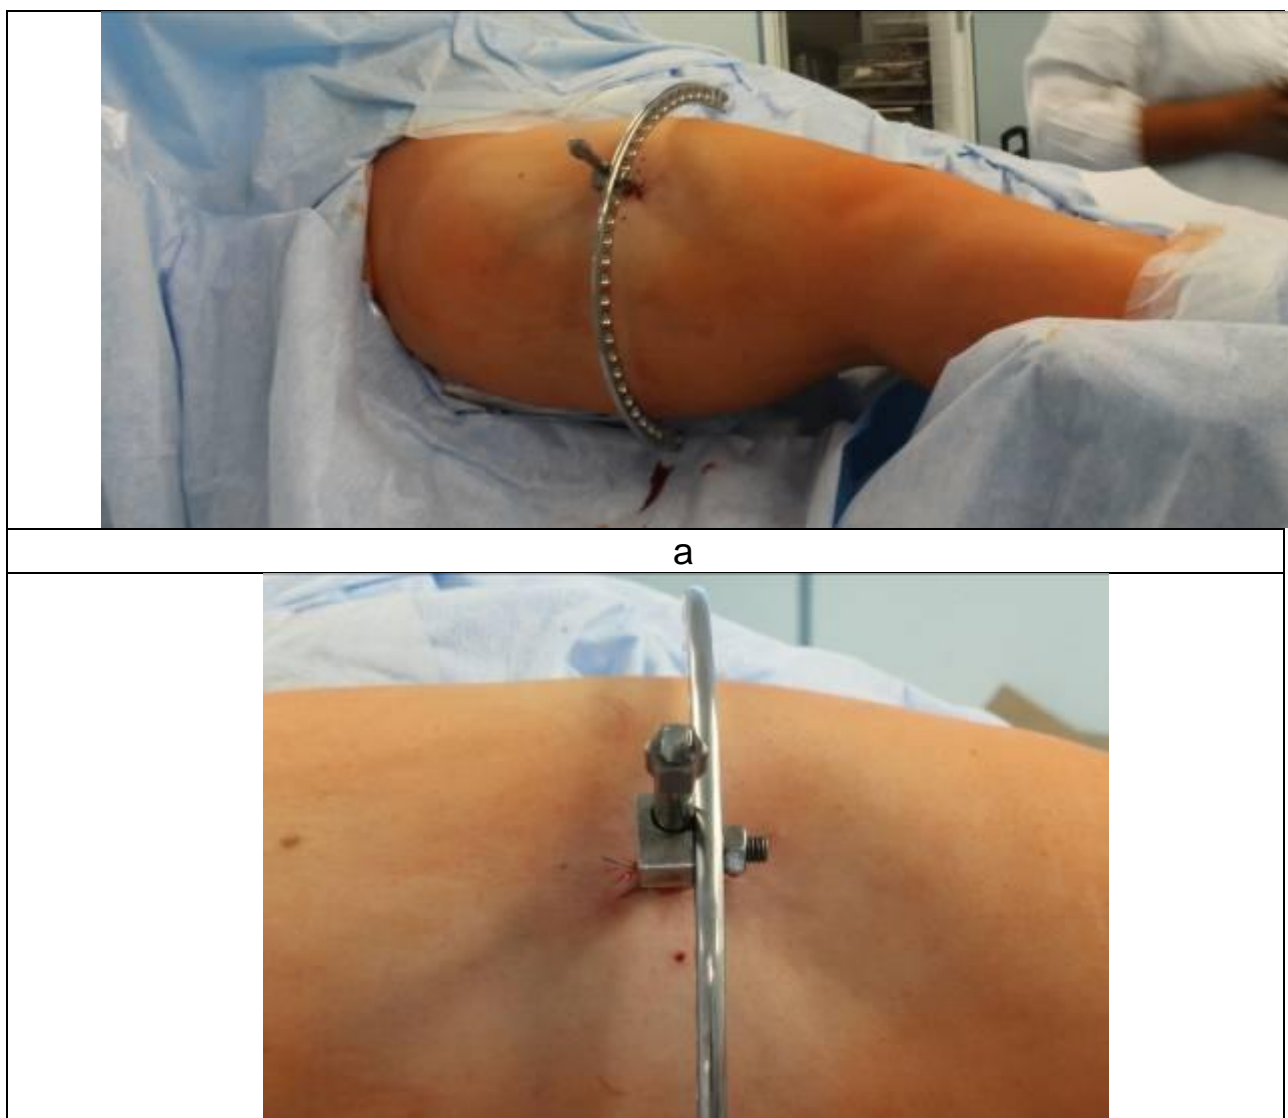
Fixation of SUV-clamp to the ring of ExFix Frame: a – appearance; b – external part of SUV-clamp is fixed to the ring by L-shaped fixator; c – SUV-clamp is fixed to the ring with the help of male post and L-shaped fixator
